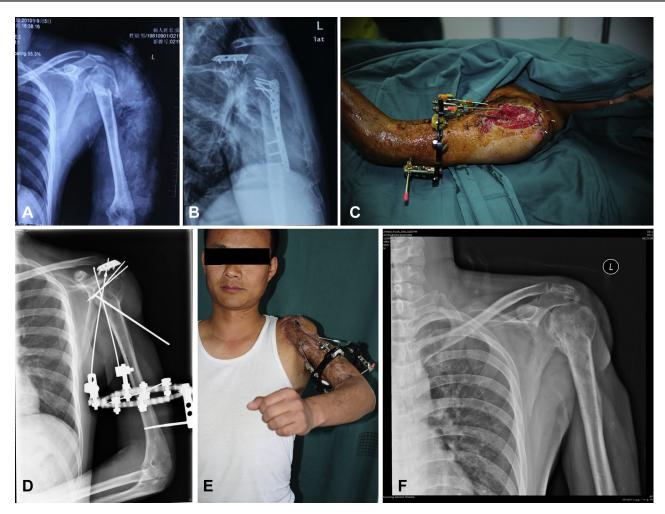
A 37-year-old man was diagnosed with left acromial and proximal humerus fractures with a skin defect caused by a car accident. (A) He underwent emergency débridement, phase 2 plate-screw internal fixation, and skin grafting. (B) A follow-up radiograph after surgery showed loss of proximal humerus fracture fixation and loosened screws. He transferred to our hospital 3 weeks after the surgery. The skin graft was partially necrotic after surgery. (C) After débridement and removal of the original internal objects, a "suspension bridge" external fixation was used. At the same time, the adjacent transposition skin flap was used to cover the wound. (D) Radiograph of the right shoulder joint after operation. (E) The patient could move the shoulder joint after surgery. (F) Radiograph of the shoulder joint after fracture unioning and removal of the external fixation.
